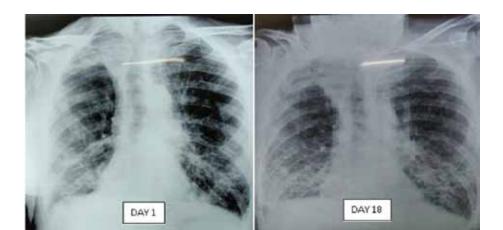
Chest Xray PA view showing Bilateral Pneumonitis
